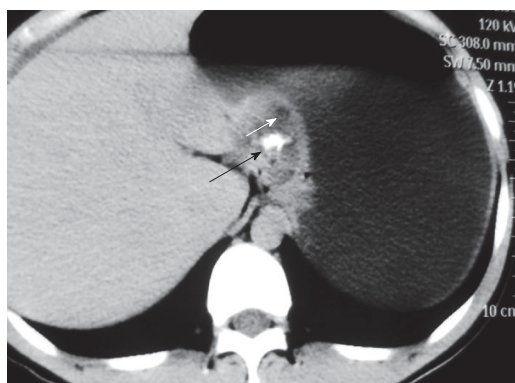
Axial CT shows a large soft tissue mass located on the inferior wall of the cardiac orifice of the stomach. The border of the mass is clear and the mass is from the stomach. The density of the mass is uneven. Low density (white arrow) indicates cystic tissue and the high density (black arrow) indicates calcifications.
